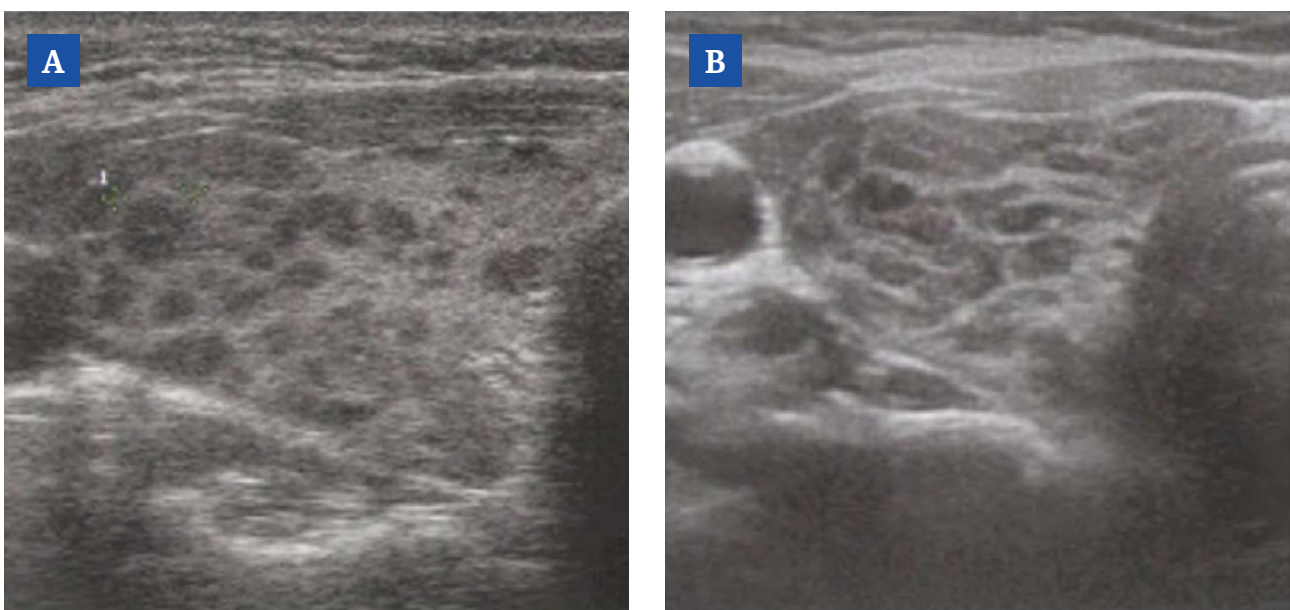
Echocardiogram of the pseudo micronodular variant of structural changes in the thyroid of patients with AIT: A – patient H., 28 years old, has been suffering from AIT for 7 years, structural changes similar to the “Swiss cheese” type; B – patient M., 32 years old, suffering from AIT for 8 years, structural changes like “honeycombs”.
